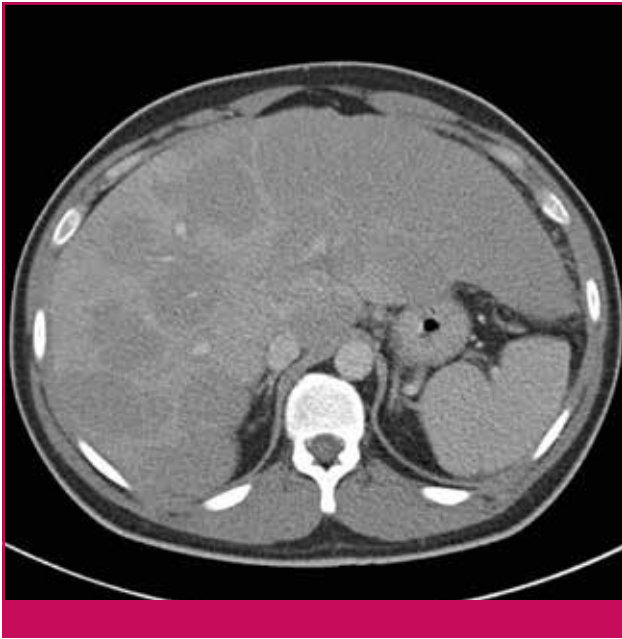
Abdominal CT scan of the patient at presentation showing multiple hepatic lesions.
